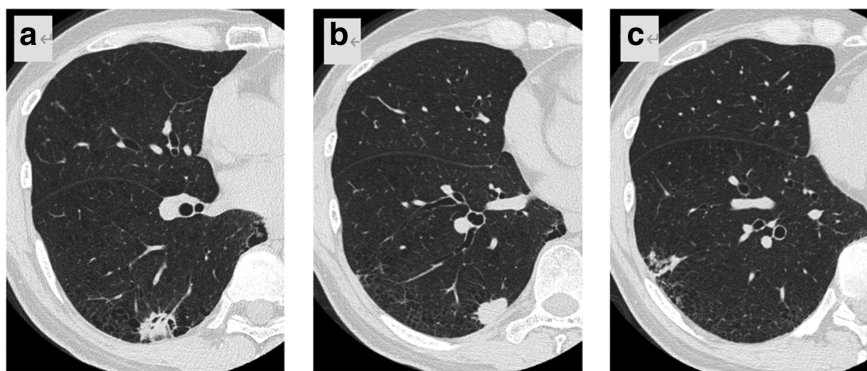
Chest computed tomography (CT) showing three nodules in the right lower lobe. (a) An irregular nodule of 25 mm in size with cavities and spiculation in the superior segment. (b) A solid well-defined nodule of 18 mm in size close to pleura in the posterior basal segment. (c) An irregular nodule which appeared to be an inflammatory change of 20 mm in size in the lateral basal segment.
